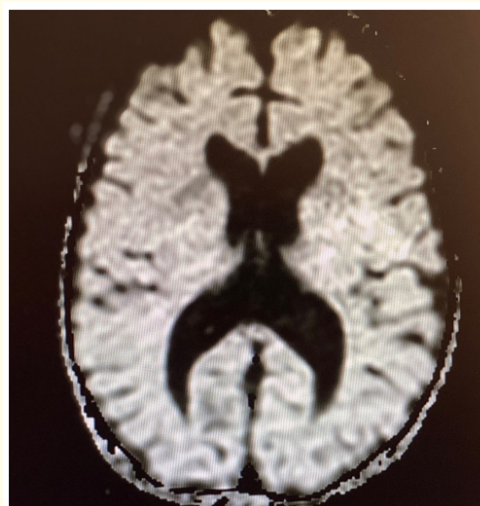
Brain MRI - mega cisterna magna.
